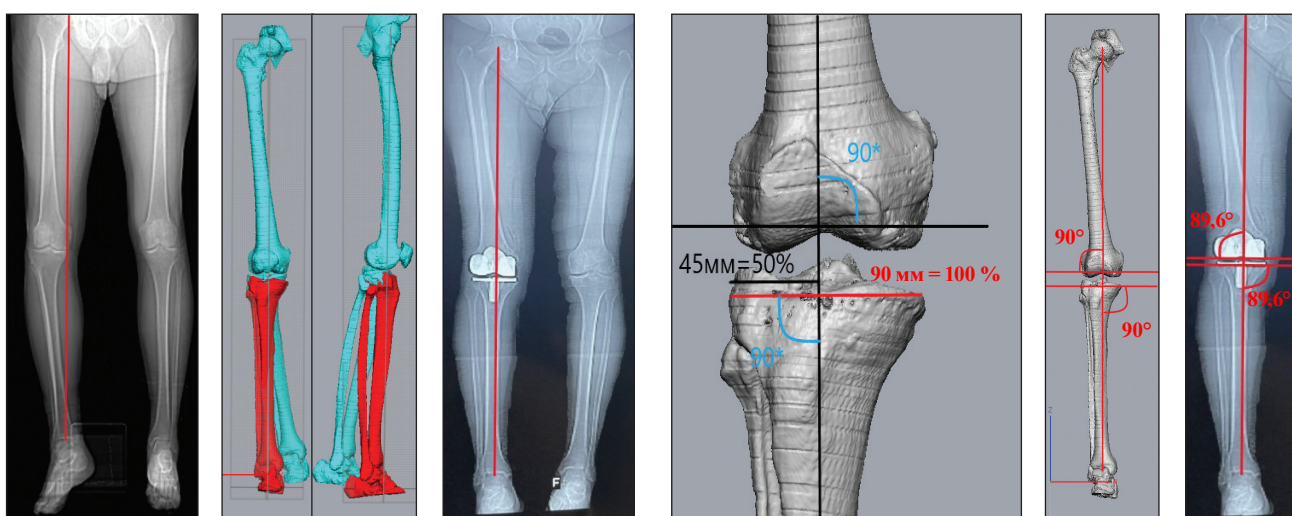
A 70-year-old patient D., result of alignment of the right lower extremity, which was carried out exactly by analogy with the previously operated on left lower extremity. X-ray after surgery on the right knee shows a symmetrical position of the mechanical axis
